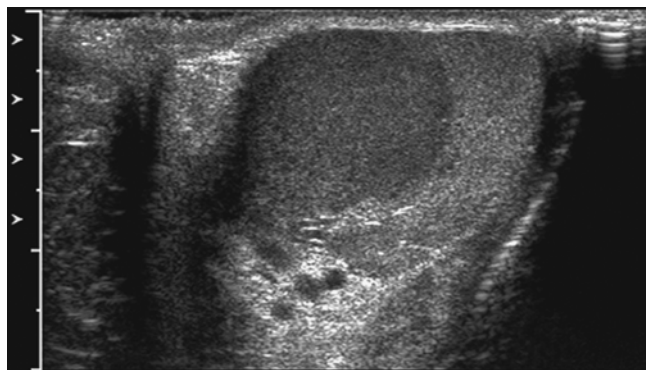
Ultrasound imaging of testicular infiltration due to non-Hodgkin's lymphoma that manifested as testicular enlargement
